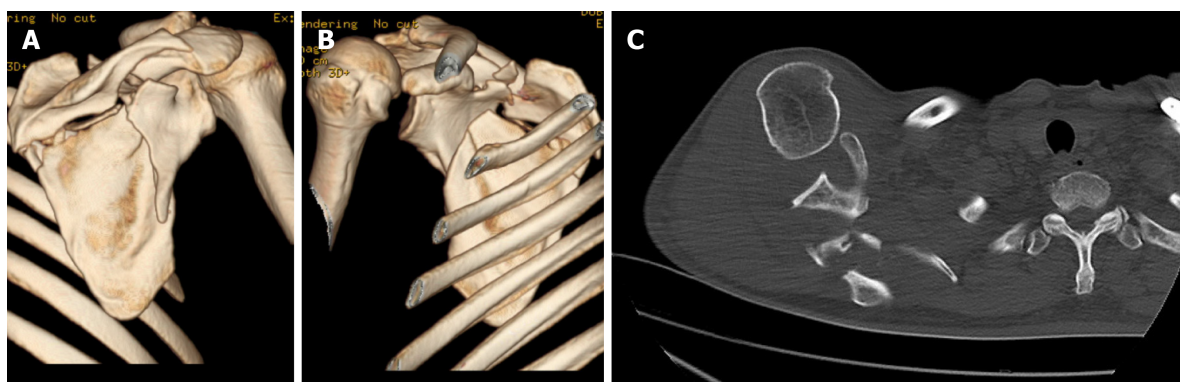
Computed tomography of the right shoulder joint. A: Posterior view of three-dimensional (3D) reconstruction; B: Anterior view of 3D reconstruction; C: Axial computed tomography image showing trans-spinous scapular neck fracture accompanied with glenohumeral joint dislocation.
